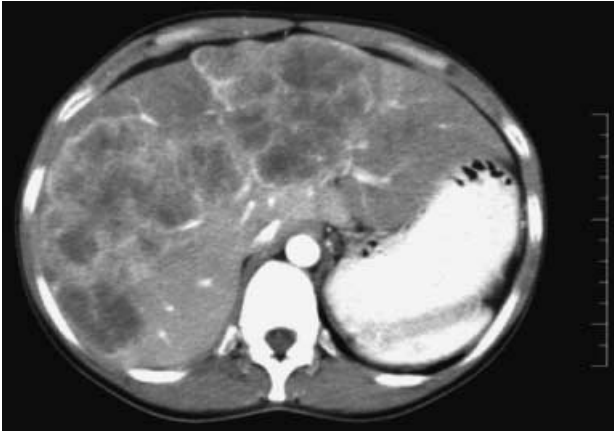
Preoperative computed tomography scan of the abdomen reveals multiple liver metastasis, which occupy the greater part of the liver.
